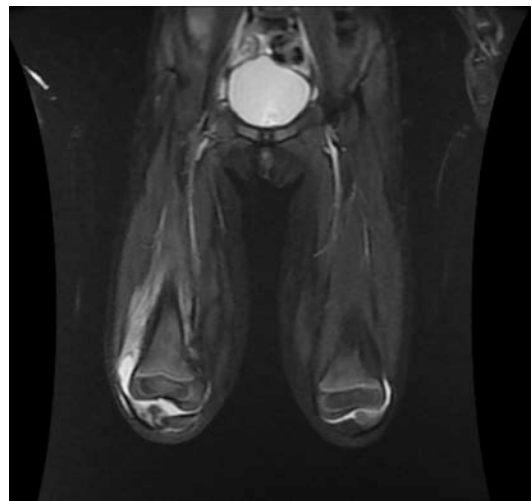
A magnetic resonance imaging of lower extremities revealed right thigh myositis, over quadriceps of right distal thigh, anterior and lateral aspect, and minimal joint effusion of right knee in coronal view
